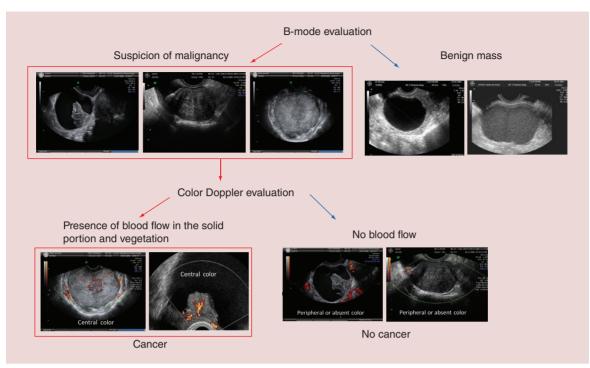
Diagnosis of adnexal malignancies by usingcolor Doppler imaging as a secondary test in persistent masses.
